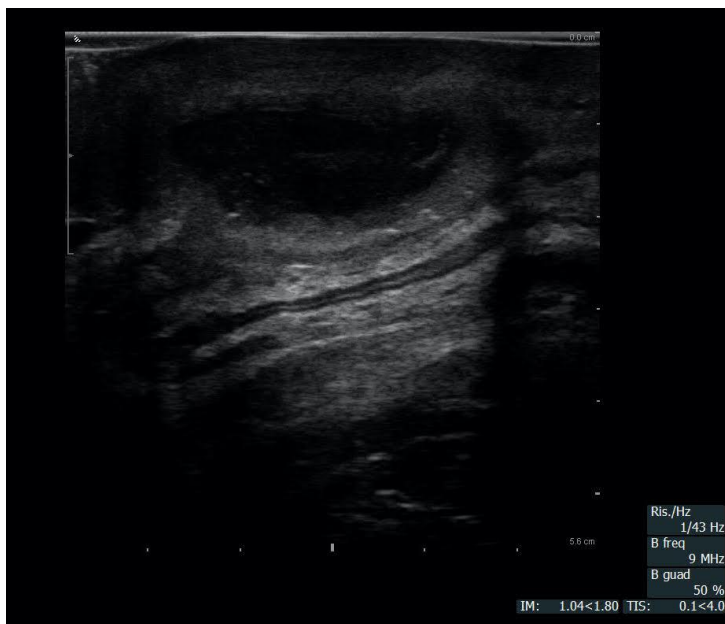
Transvaginal ultrasound – linear probe midsagittal view: the relationship between the endometrioma and the ano-rectal canal is demonstrated
